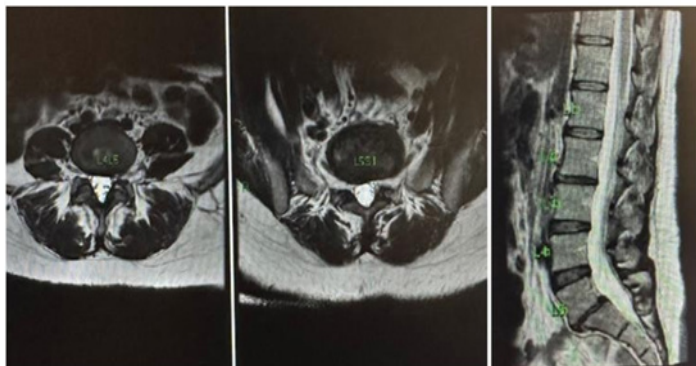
Recent Nuclear Magnetic Resonance Imaging demonstrating good evolution of herniated disc L5-S1.
